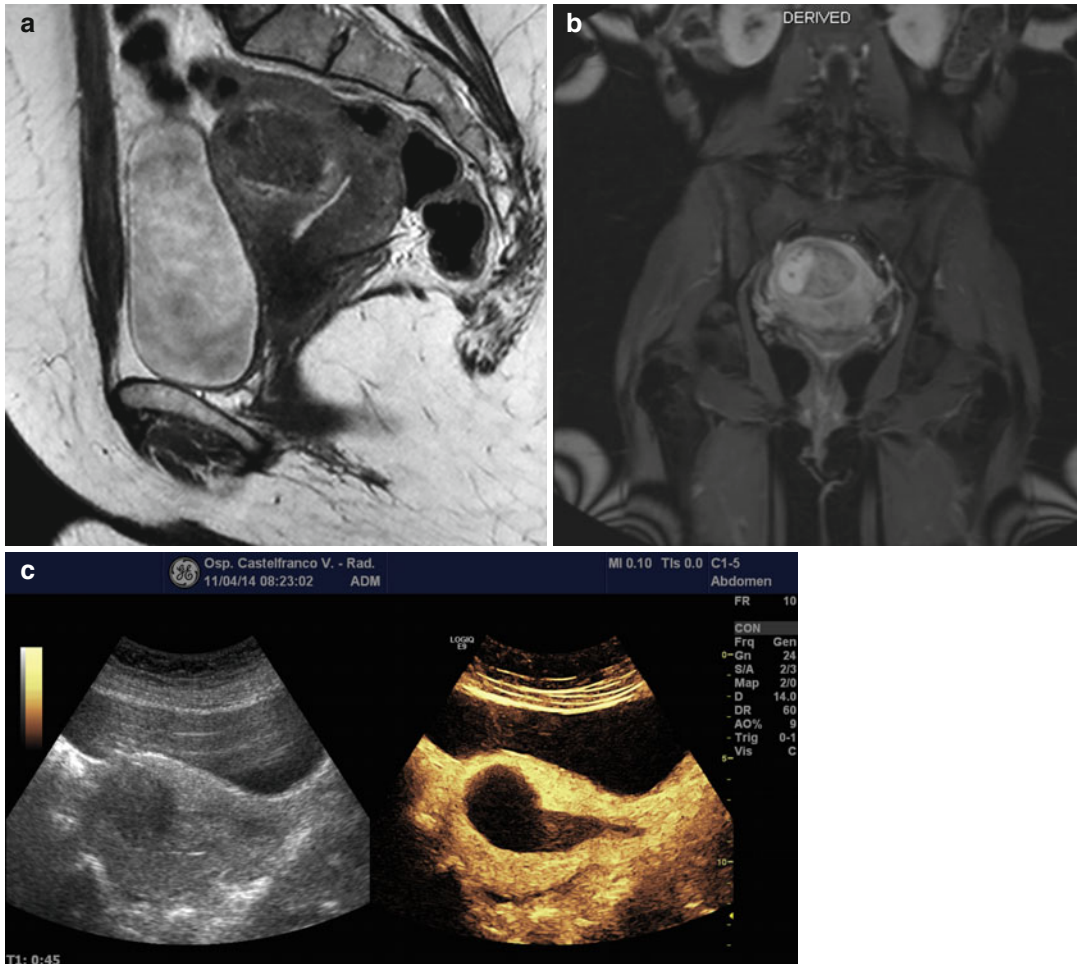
MR images of an intramural uterine fibroid pre-procedure and 2 months post-procedure CEUS image. Sagittal T2-weighted image (TR 3,700 ms, TE 80 ms) (a) shows a large intramural heterogeneous low-signal-intensity fibroid; sagittal contrast-enhanced fat-suppressed T1-weighted image (TR 4 ms, TE 2 ms) (b) shows
